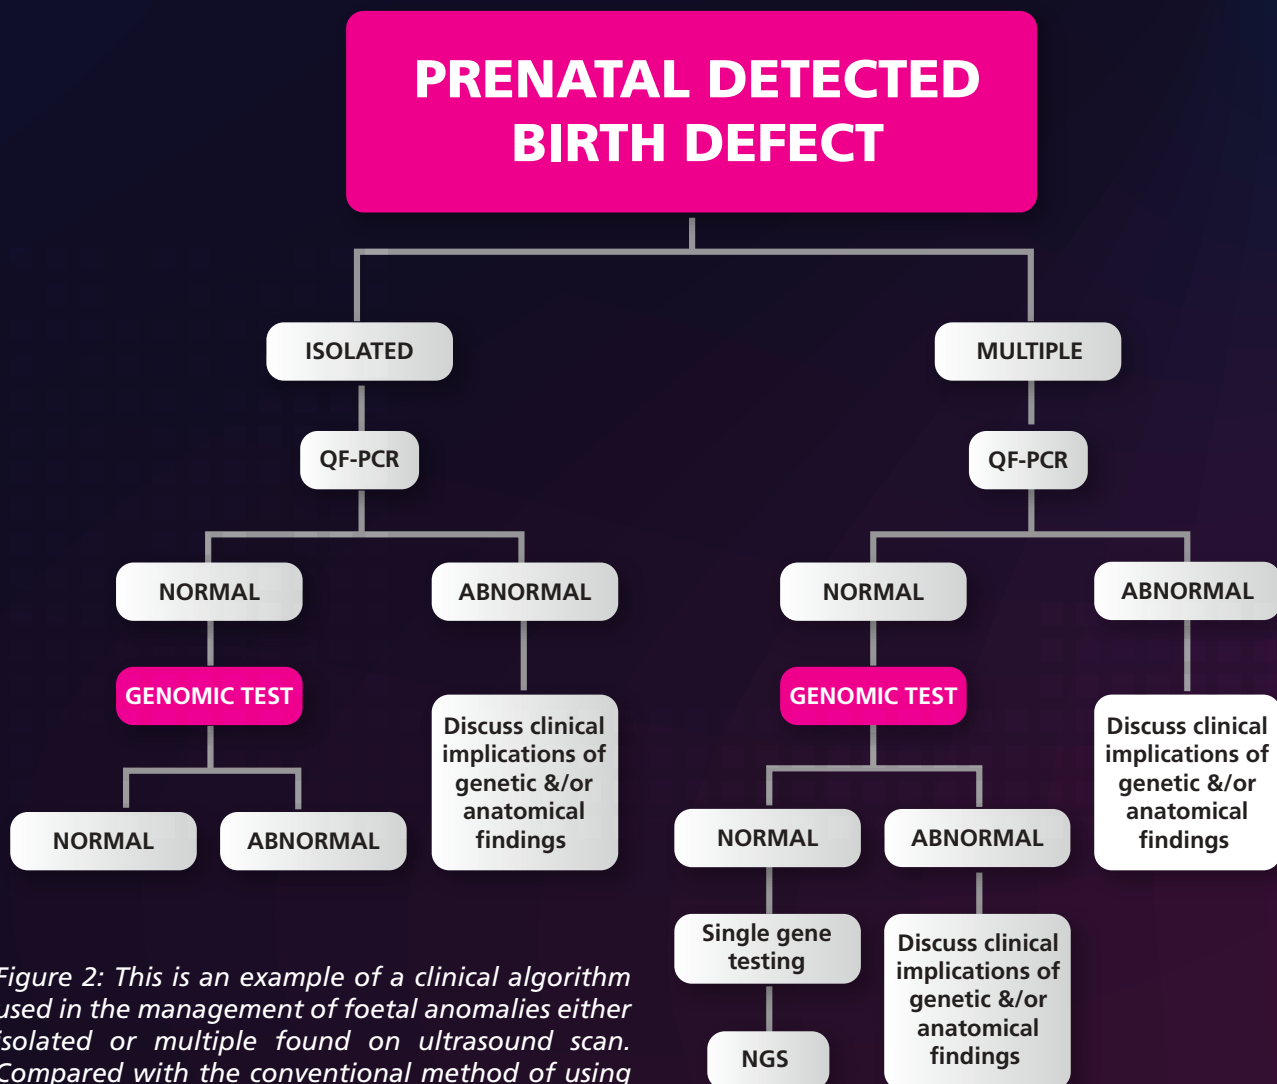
This is an example of a clinical algorithm used in the management of foetal anomalies either isolated or multiple found on ultrasound scan. Compared with the conventional method of using genomic testing, the authors were able to improve the diagnostic yield to 50%
